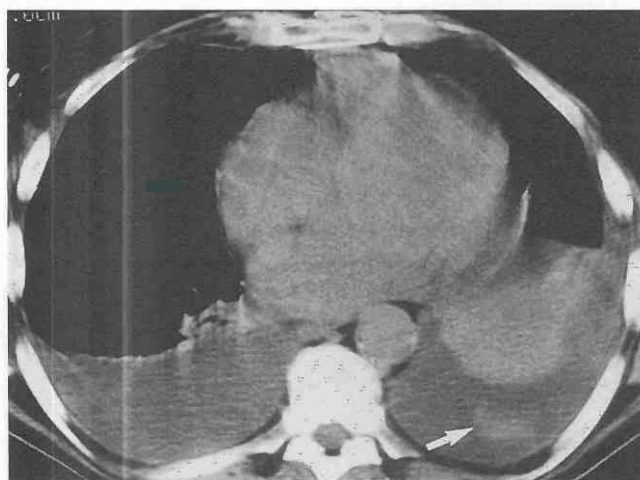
Hemothorax following endomyocardial biopsy in a 59-year-old man who developed mild shortness of breath after the biopsy. Nonenhanced CT scan shows a high-attenuation left pleural effusion consistent with hemothorax (arrow). The patient recovered without intervention. (From Knisely BL, Mastey LA, Collins J, Kuhlman JE: Imaging of cardiac transplantation and complications. Radiographics 19:321, 1999.)
